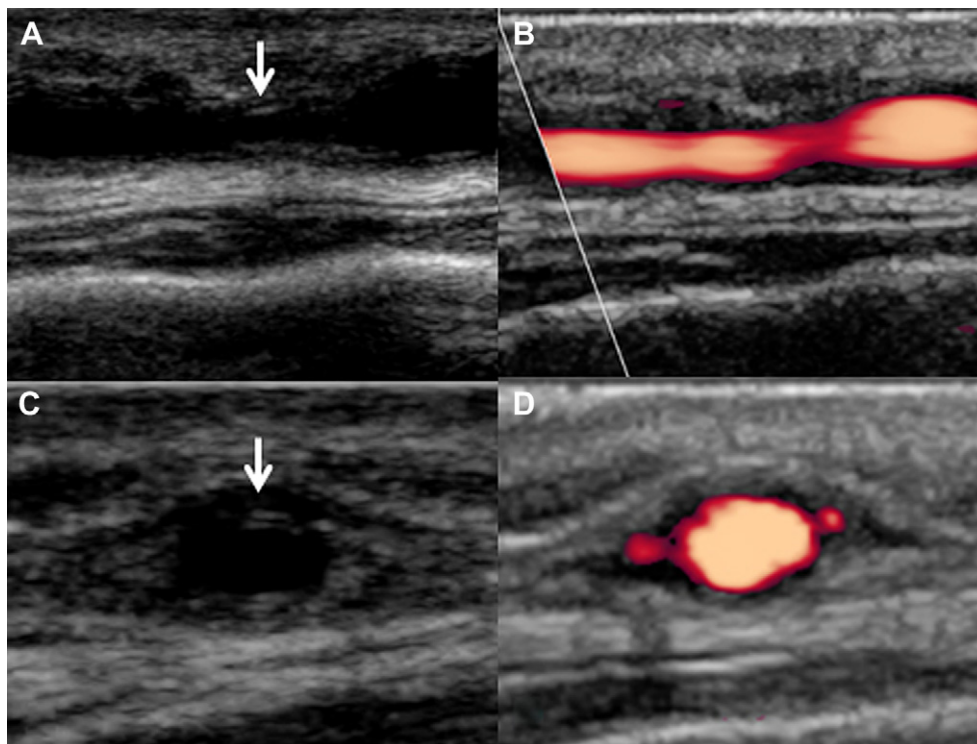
A 79-year-old man with temporal arteritis. (A) Longitudinal gray-scale and (B) power Doppler ultrasonography of the left temporal artery showing wall thickening (arrow in A) that resulted in stenosis. (C) Transverse gray-scale and (D) power Doppler ultrasonography showing intima edema that formed a hypoechoic area (arrow in C) in the periphery of the lumen (halo sign).
